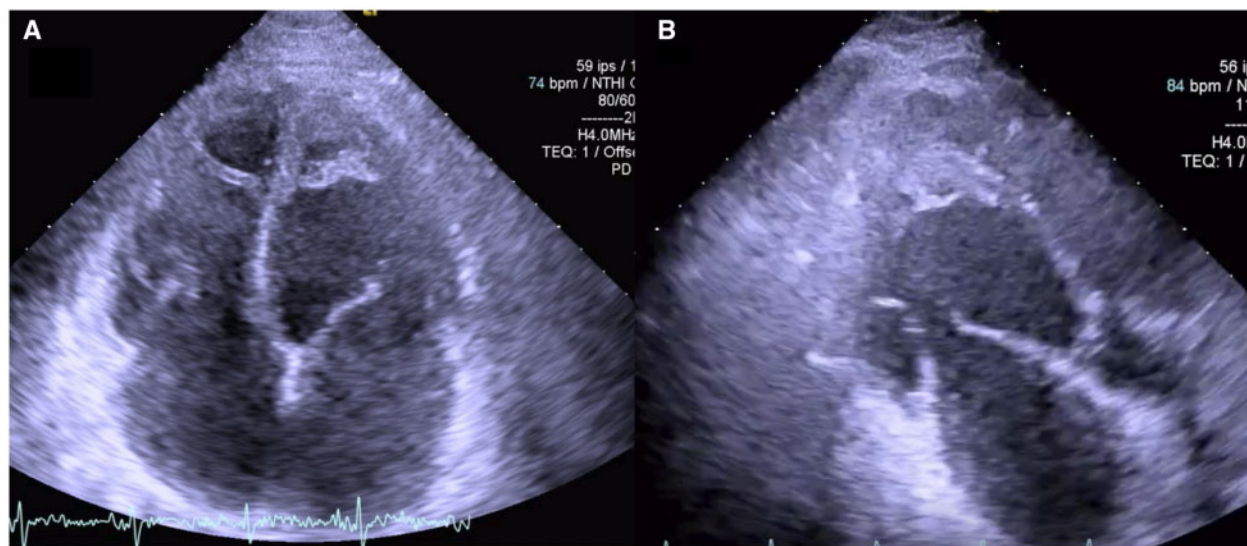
Transthoracic echocardiography showing a heterogeneous mass at the left ventricle apex. (A) Apical four-chamber view; (B) apical two-chamber view.
